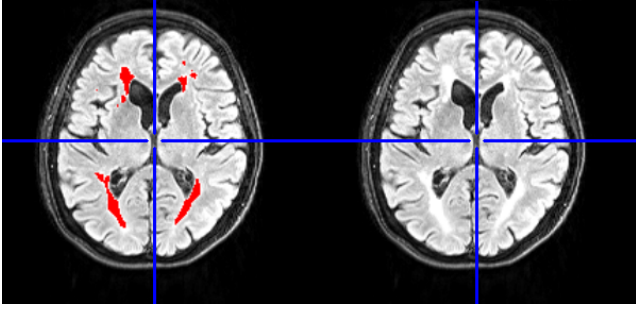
WMH lesions segmentation. Left panel, in red the overlapped binary mask obtained by the U-net model. Right panel the FLAIR image
